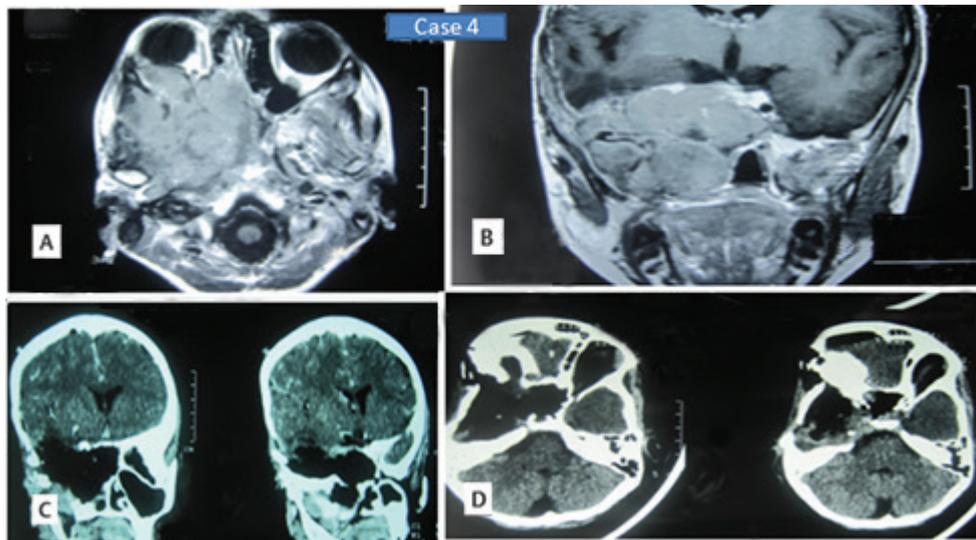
Case 4. (A) Preoperative axial and T1 MRI images showing clear cell meningioma involving ITF, rt orbit, sphenoid with intracranial extradural extension. (B) Preoperative axial and T1 MRI images showing clear cell meningioma involving ITF, rt orbit, sphenoid with intracranial extradural extension. (C) Postoperative coronal CT scan showing complete removal of tumor. (D) Postoperative coronal CT scan showing complete removal of tumor. CT, computed tomography; ITF, infratemporal fossa; MRI, magnetic resonance imaging.
